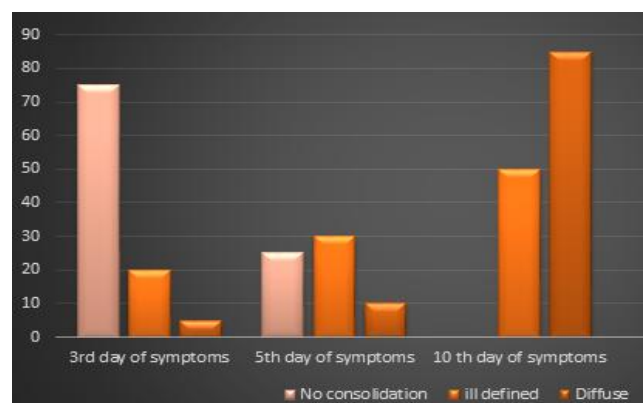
Amount of consolidation spread on HRCT chest on each time series in percentages.
